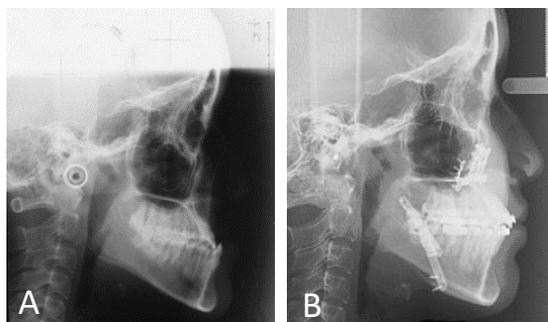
Lateral Cephalometric Radiographs: (A) Skeletal class III mandibular protrusion before surgery, (B) Changes of skeletal pattern after surgery
